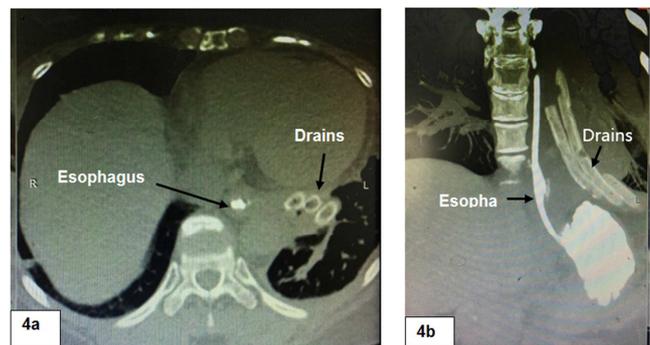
Post-operative computed tomography with hydro-soluble contrast ingestion showing no extraluminal leak and good integrity of esophagus.
